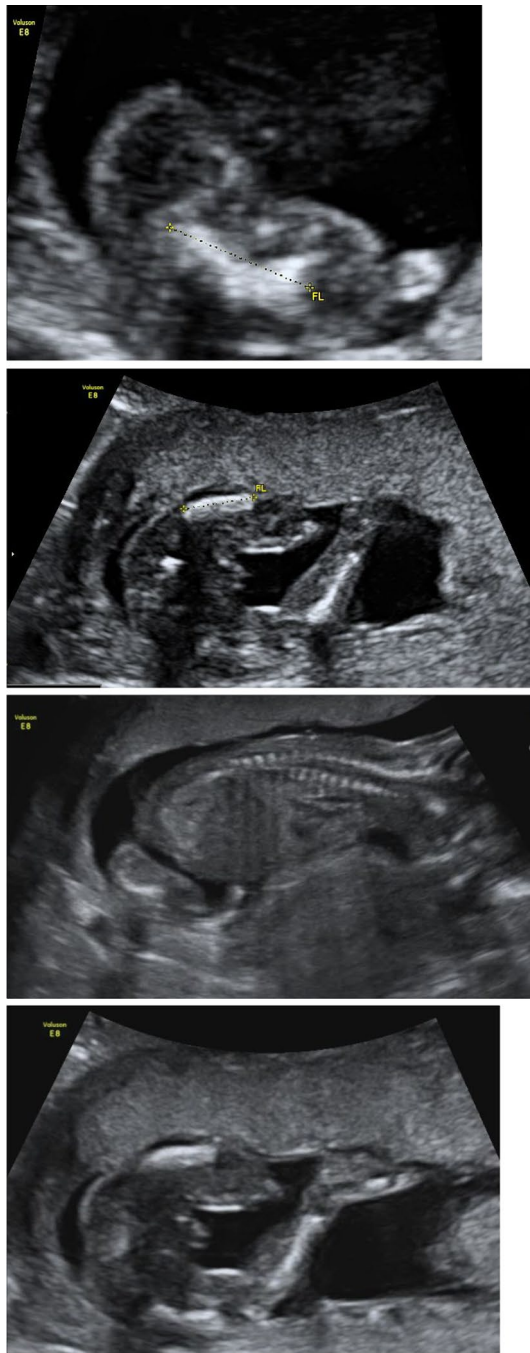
Ultrasonographic view of bowed and angulated femur in different positions at 17th gestational week
